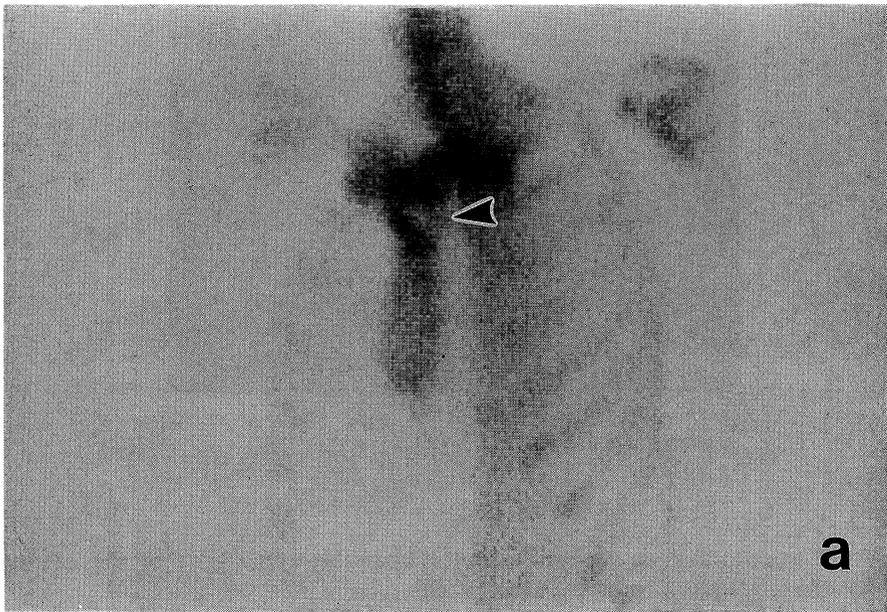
Bone scintigraphy showed a photon deficient area with surrounding hot lesion in the sternum.
